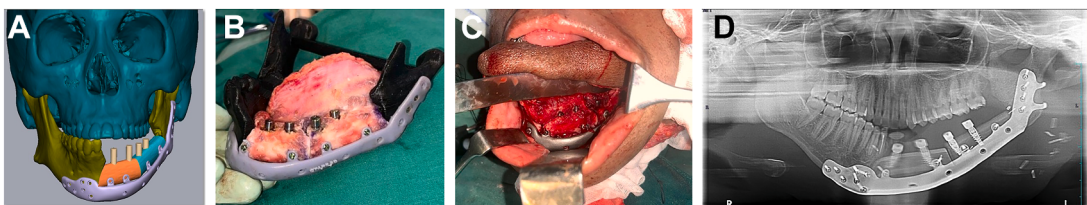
(A–D) Secondary reconstruction of mandible using a PSI and FOCFF with dental implants. (A) VSP the use of PSI and dental implant. (B) Dental implant placement using the PSI model. (C) Intraoperative picture of the PSI and dental implants. (D) Postoperative orthopantomogram.
